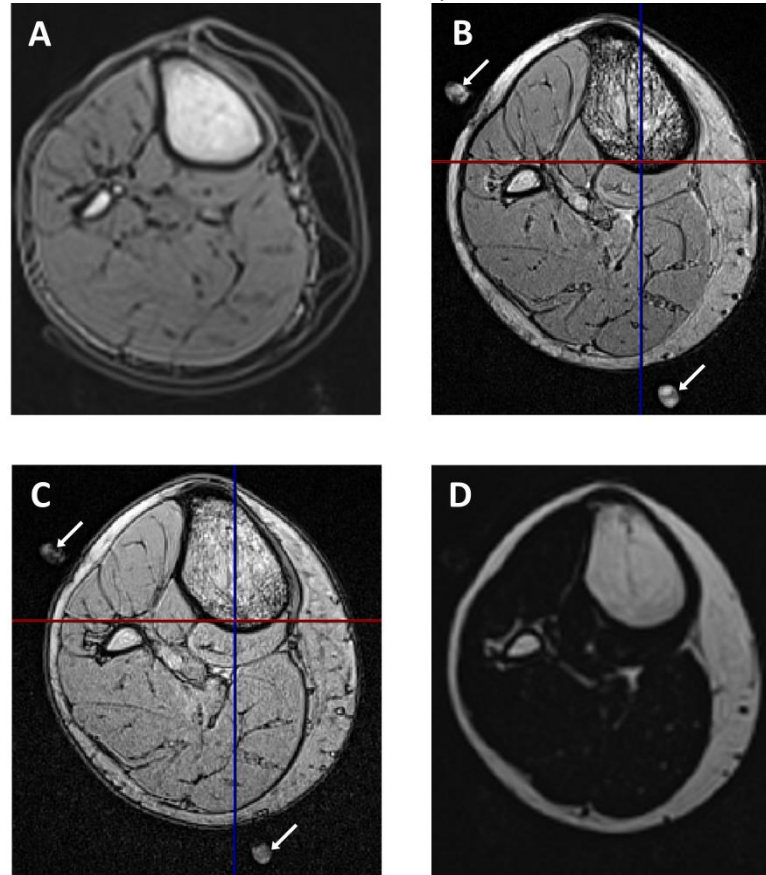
Transverse MRI slices through calf at baseline, A: out of phase, in-slice resolution 1.3 x 1.3 mm, B & C: out of phase, in-slice resolution 0.6 x 0.6 mm, TE: 12.30 ms and 6.15 ms respectively (white arrows show oil tablets in-situ), D: fat saturated, in-slice resolution 0.6 x 0.6 mm
